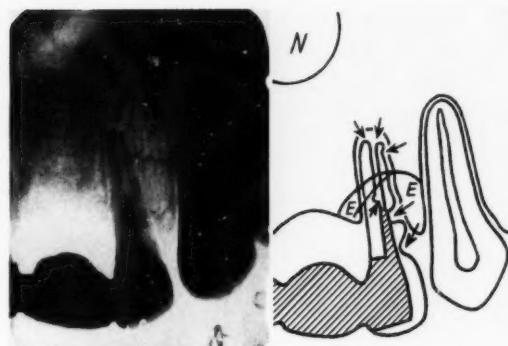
Roentgenogram and tracing made 14 months after the root canal filling
